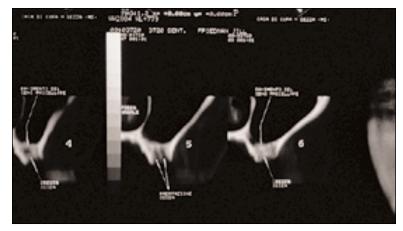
(*Left*) Panoramic radiograph showing severe atrophy with maxillary sinus expansion on the left side.
